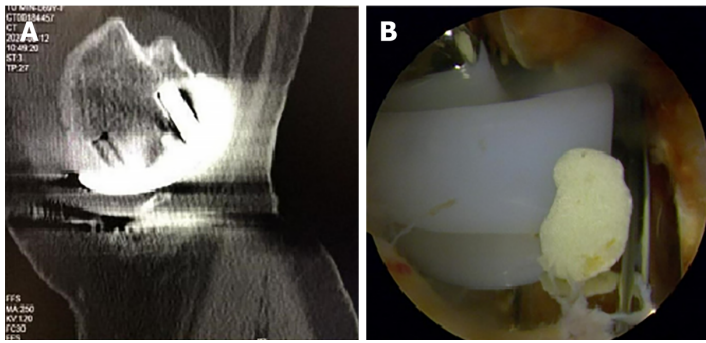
Treatment process (left knee) for Patient 5. A: Dual computed tomography image showing that there was a bone-free body between the tibial prosthesis and the femoral prosthesis; B: Residual bone cement was found during arthroscopic exploration.
